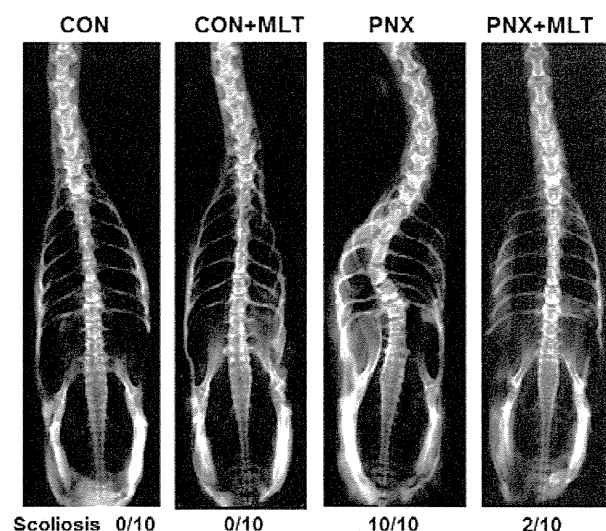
Posteroanterior radiographs of spine. A straight vertebral column in sham-operated (CON) and sham-operated (CON + MLT) and pinealectomized (PNX + MLT) chickens with melatonin treatment. Scoliosis with a single curve in pinealectomized chickens (PNX). Note the presence of more complicated deformity with vertebral rotation towards the convexity of the curve. The vertebral body at the apex of the curve is compressed (from above downward) on the concave side showing wedge-shaped deformity.
